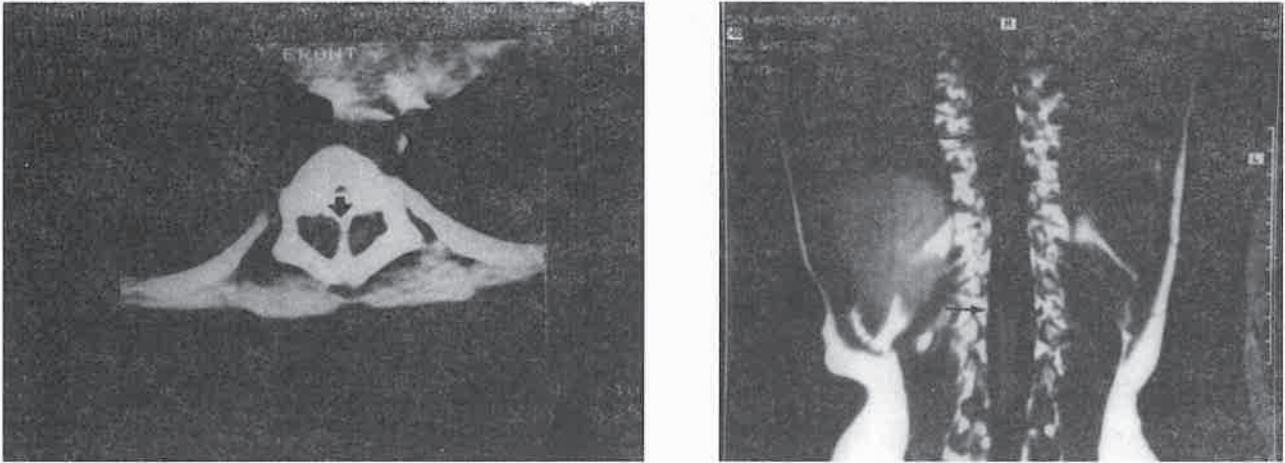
a and b: CT-scan showing median bony septum at thoracal 8 (arrow).
